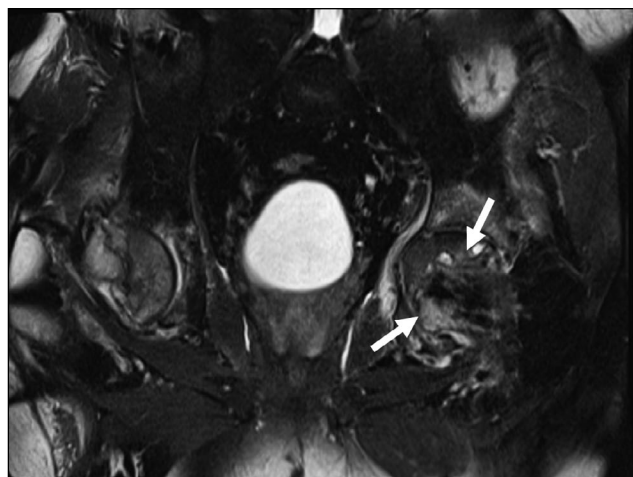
Magnetic resonance imaging showing aseptic necrosis of the head of the left femur in a patient infected with coronavirus (arrows).
